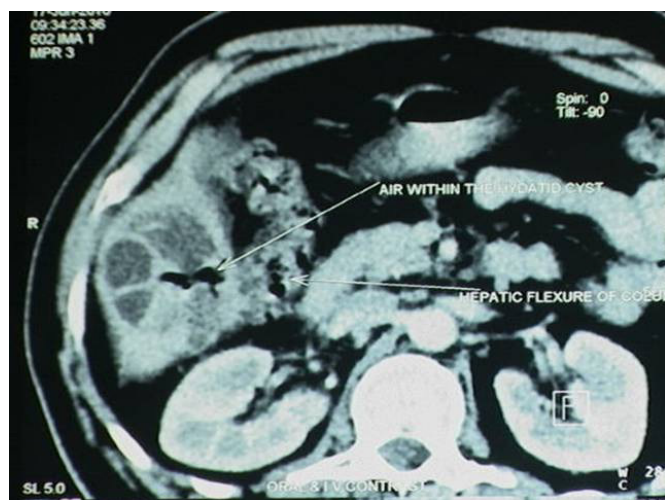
CT scan showing air within cystic lesion with adherence to hepatic flexure suggestive of a colonic communication
